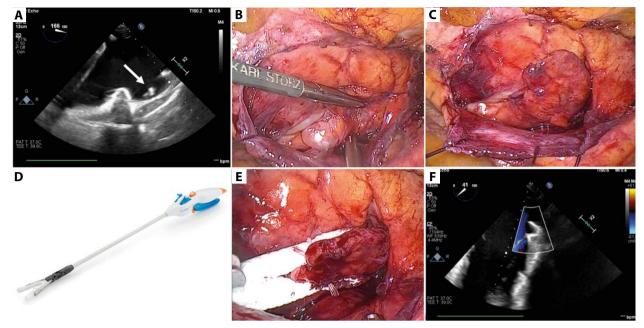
Intra-operative transesophageal echocardiography (A) the white arrow points to the dense thrombus in the left atrial appendage (LAA); thoracoscopic adhesions removal and LAA visualization; pericardial traction sutures in place (B). LAA fully mobilized (C). AtriClip® PRO-V thoracoscopic device (D). PRO-V clip placement (E). Echocardiography shows acceptable LAA closure (F)
